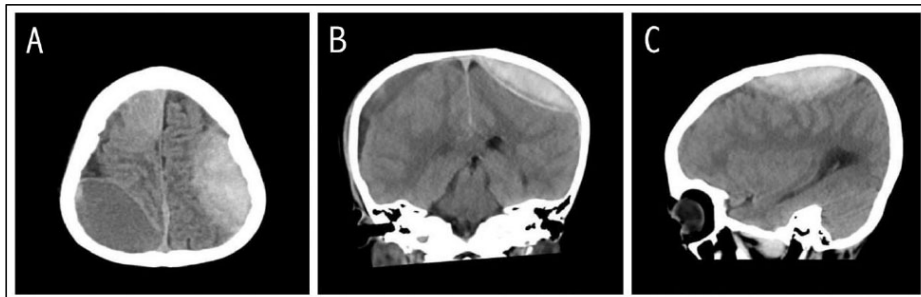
Head computed tomography scan showing acute subdural hematoma on the left parietal lobe. A: Axial, B: Sagittal, and C: Coronal slice.
